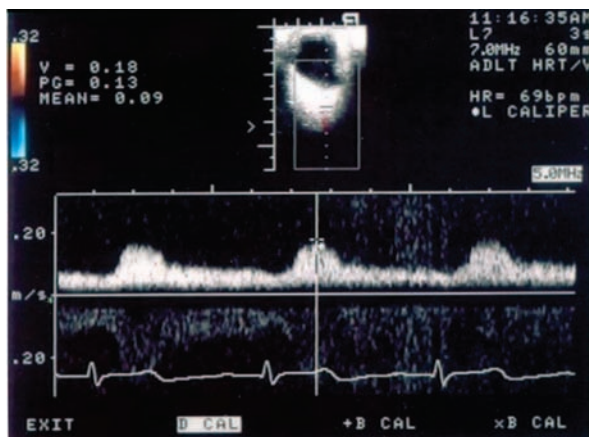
Color Doppler imaging of the ophthalmic artery, before aortic clamping, displays a pulsatile and positive waveform with peak systolic velocity of 18 cm/sec.
